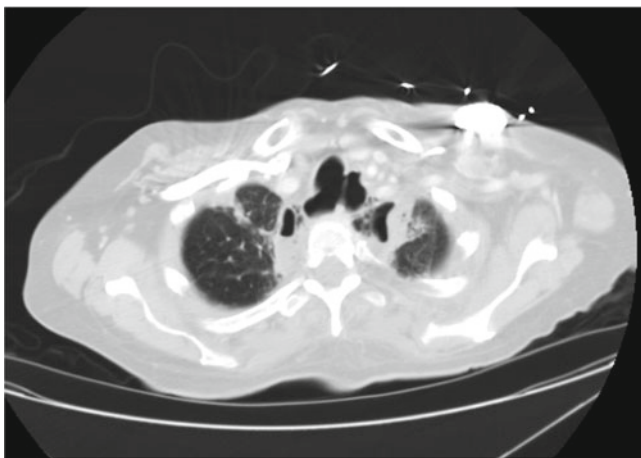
CT scan of a tracheo-esophageal fistula after chemotherapy and radiation therapy for esophageal squamous cell carcinoma
